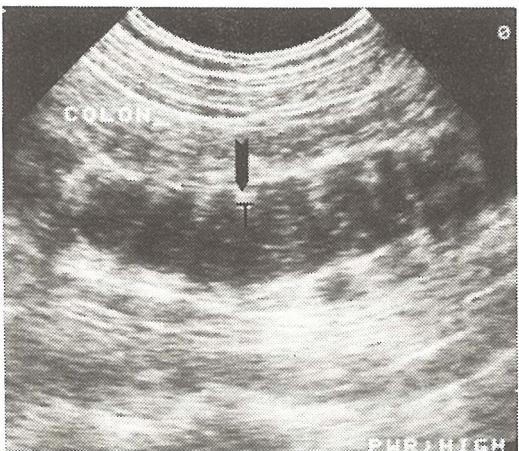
Sonographic scan of typically distended large bowel in cancer proximity (T)
